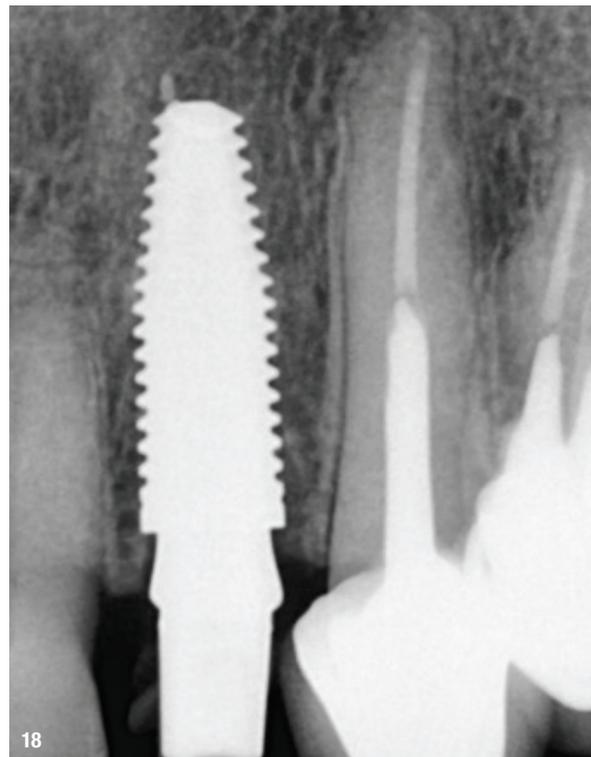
Post-op radiograph.
